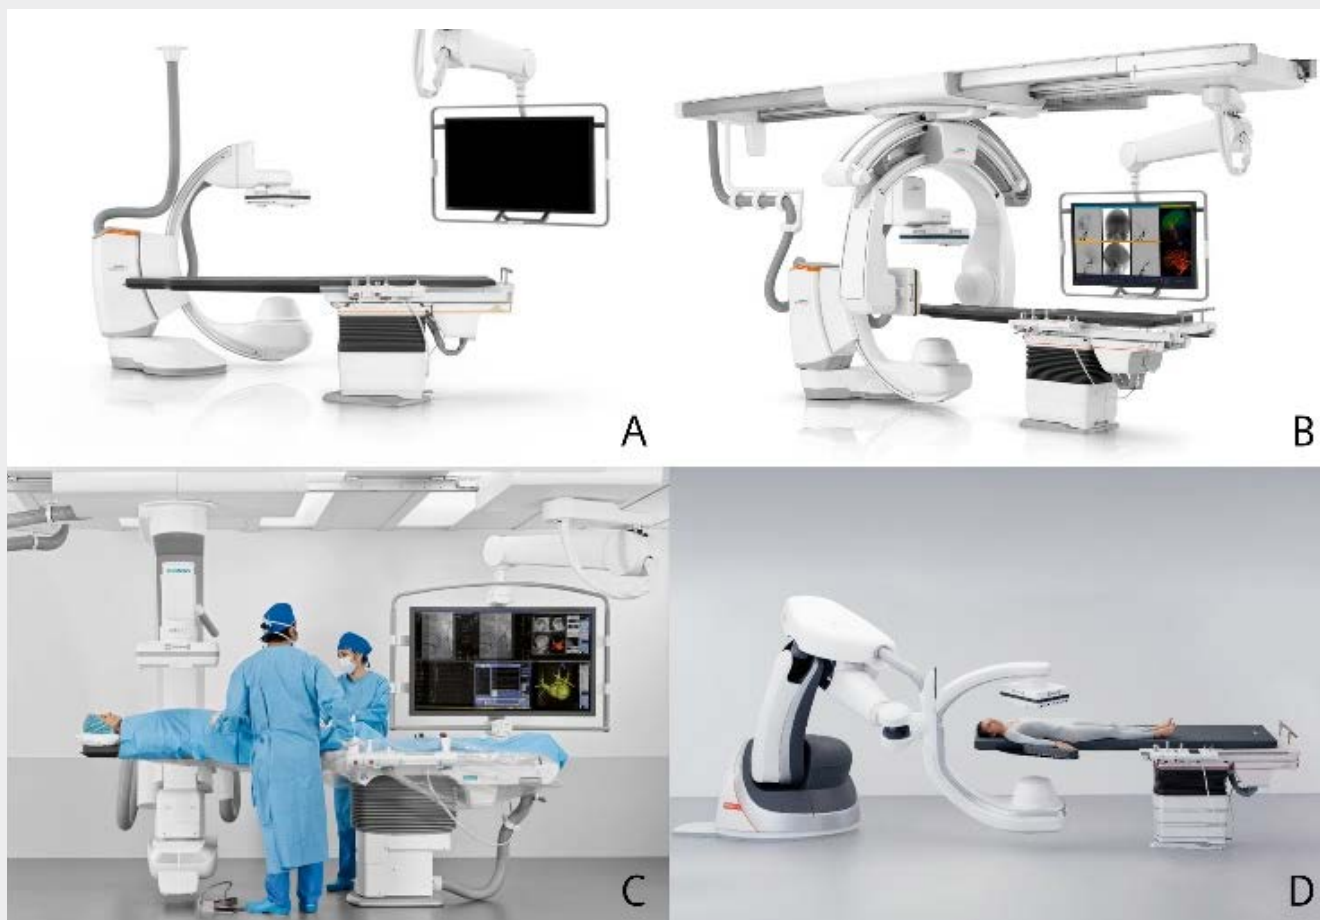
Siemens fixed angiographic systems come in different configurations: Floor (A); Biplane (B); Ceiling (C); and Robotic (D). All systems are capable of performing CBCT.
